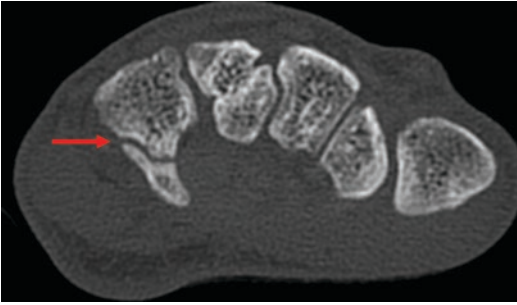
CT scan of a hamate hook base fracture (see arrowhead)
